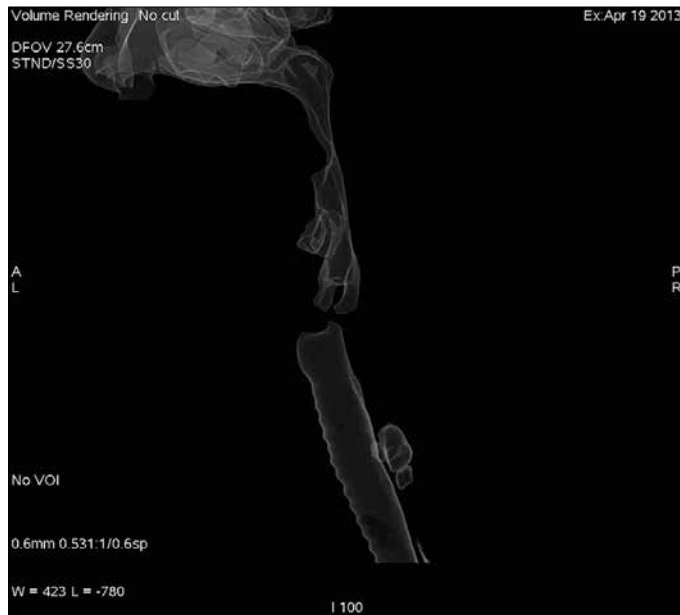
On 3D VR CT imaging, right paratracheal diverticulum from the left lateral aspect
